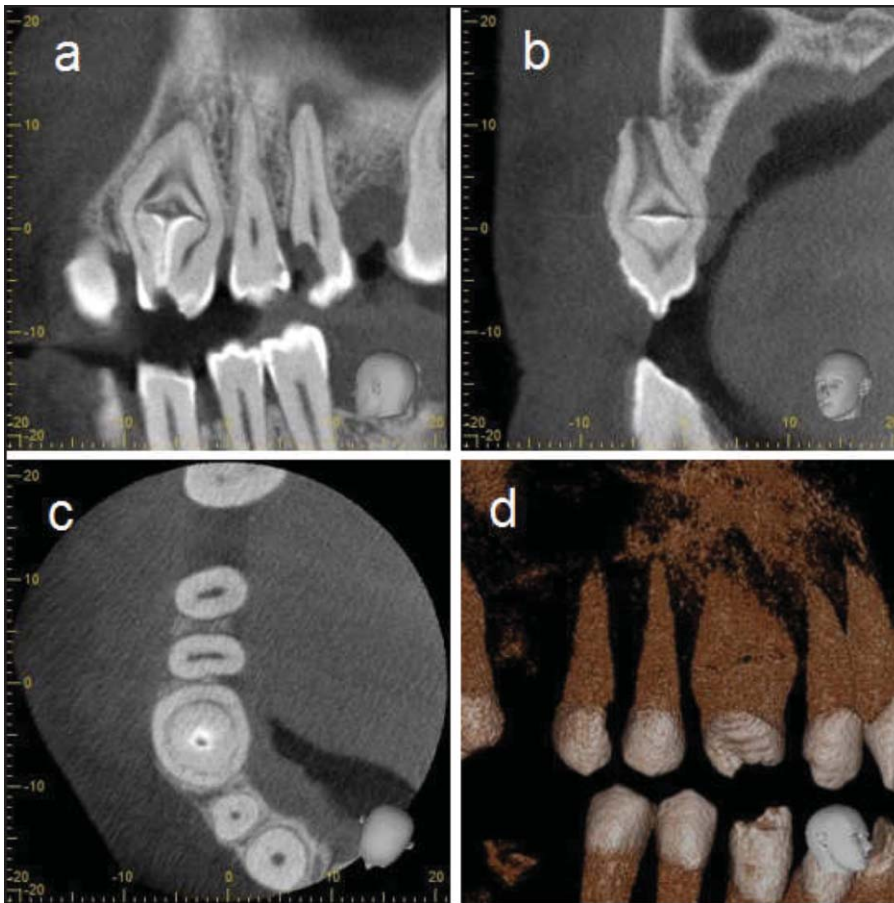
a-d) Cone-beam computed tomography sections.
